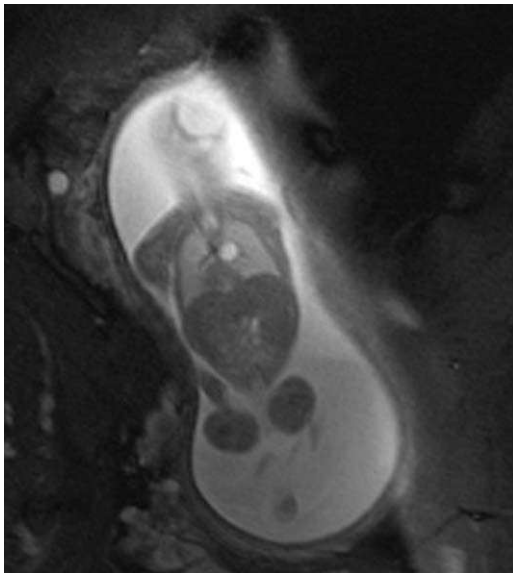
Coronal MR image of a fetus at 19 weeks' gestation referred for congenital diaphragmatic hernia. Confirmatory sonogram showed an anechoic cyst in the chest, absent stomach below the diaphragm, and no mediastinal shift. Because of the lack of mediastinal shift, the confirmatory sonographic diagnosis was believed to be a combination of foregut duplication cyst and esophageal atresia. MR showed the diaphragm to be intact. Without a confirmatory US, this type of finding would suggest that MR showed increased information compared with US. Because a confirmatory sonogram was performed, the authors concluded that MR showed no new information and did not change patient care.
